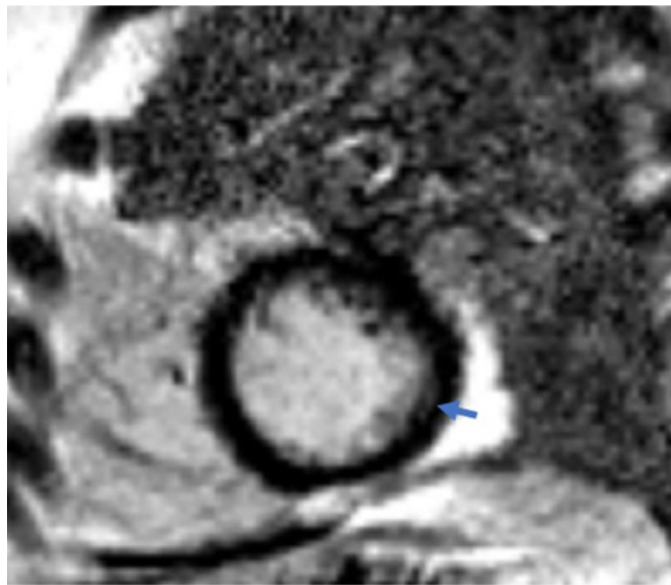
Short-axis delayed contrast-enhanced PSIR cardiac MR image, showing focal subendocardial transmural and subepicardial enhancement areas, mostly in the inferior and inferolateral left ventricular walls.
